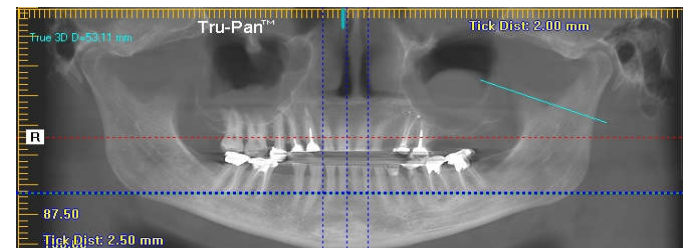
Panoramic reconstruction CBCT image showing fracture of the root
